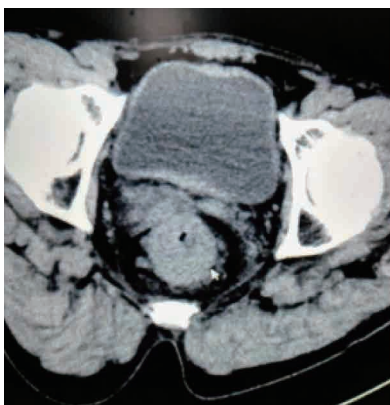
2019.5.6 Abdominal CT: The rectal wall is thickened in a circular shape, with rough edges, and multiple enlarged lymph nodes nearby (T4N2M0)
